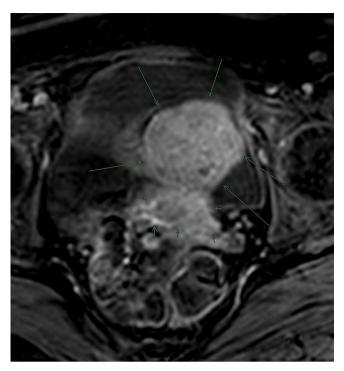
MRI found a pelvic mass (long arrows) probably depending on the uterus (short arrows).
